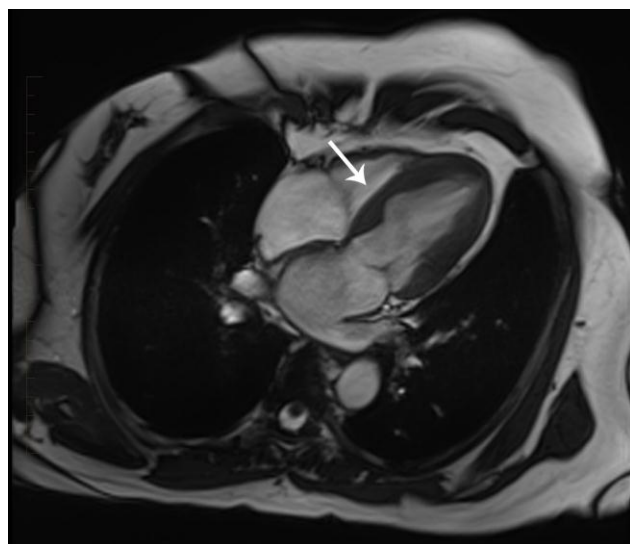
CINE MRI four chamber view demonstrates the appearance of focal ballooning of the mid-cavity interventricular septum (marked with an arrow). This appearance is caused by failure of the mid-septum to contract and thicken during systole.
